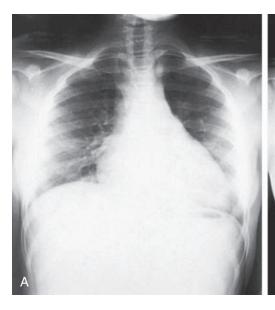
Probable pulmonary infarction in a 15-year-old patient with HbSS. A, Frontal radiograph shows consolidation and a small pleural effusion posteriorly in the right lower lobe. B, Radiograph obtained <24 hr later shows massive right middle and lower lobe consolidation and effusion. No organisms could be cultured. The diagnosis of "probably pulmonary infarction" was established clinically. (Courtesy Dr. Thomas L. Stovis, Children's Hospital of Michigan, Detroit. From Kuhn JP, Stovis TL, Haller JO: Caffey's Pediatric Diagnostic Imaging, 10th ed. Philadelphia: Mosby, 2004. p. 1087.)
